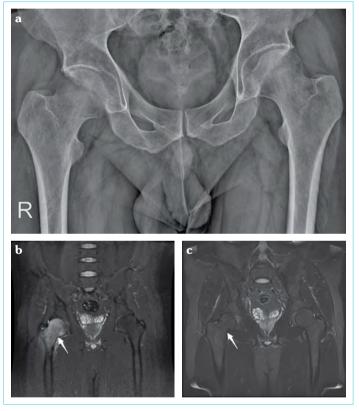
(a) Hip X-ray with normal findings. (b) MRI showing T2w hyperintense signaling involving right femur head and neck consistent with bone marrow edema. (c) Resolution of the right femoral edema
